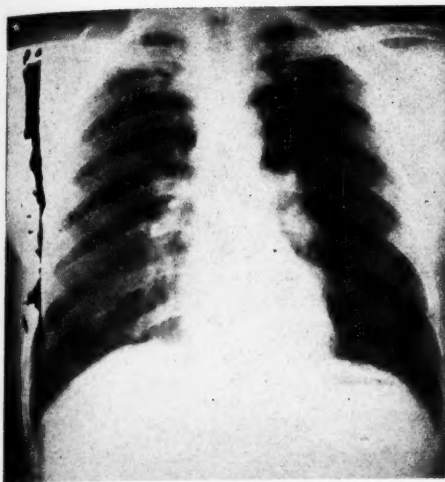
Artefact caused by leakage of x-rays in cassette storage box where lead protection had become displaced. Only the 14 X 17 inch films were affected, as the others did not reach this height.
